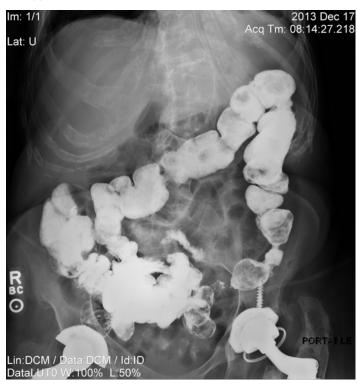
The day after osteopathic treatment was administered, X-ray imaging revealed movement of the stool into the colon. No stool was appreciated in the small bowel.
